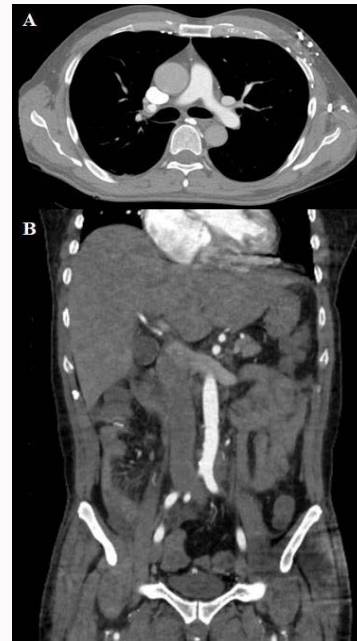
Postoperative six-month follow-up computed tomography. (A) Axial view, (B) Coronal view demonstrating the unremarkable pulmonary arteries, abdominal aorta, and bilateral common iliac artery without evidence of thrombus.
